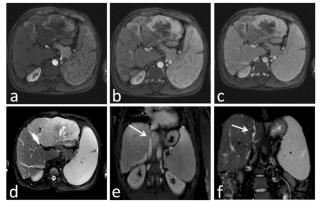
Multiphasic magnetic resonance imaging of the abdomen shows a large mass lesion in segments III and IV, on the background of a cirrhotic liver. The mass shows progressive enhancement on (a) arterial, (b) portal, and (c) venous phases on contrast imaging. The stenotic intrahepatic and suprahepatic part of the inferior vena cava also can be visualized: arrows in (e) and (f).
